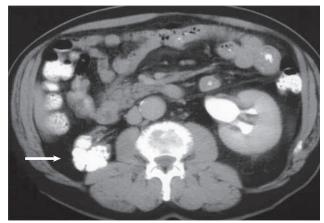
Calcified kidney. Contrast-enhanced CT image shows contracted calcified right kidney (arrow) and normal opposite side.
